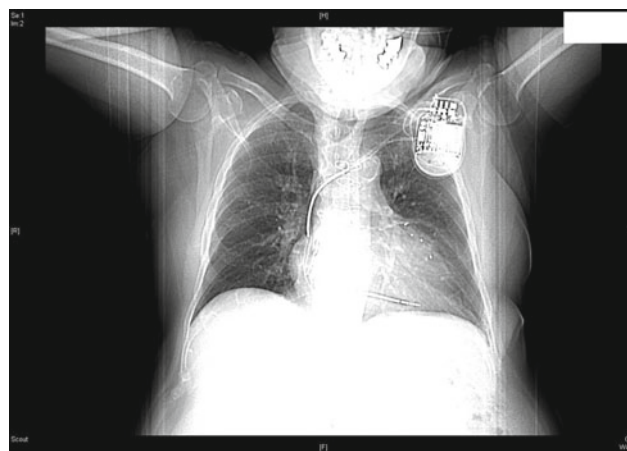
Preoperative chest X-ray. Note the ICD pulse generator in the left upper quadrant of the chest and the thick coils from the device coursing into the right ventricle. Midline sternotomy wires are evident from prior bypass surgery
